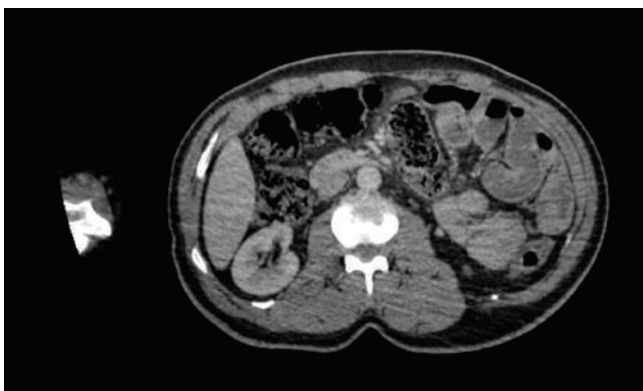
Appearance suggestive of midline duodenal internal herniation on contrast-enhanced abdominal CT. Dilatation up to 3 cm and air-fluid levels are observed in the jejunal loops at the same levels, consistent with subileus.
